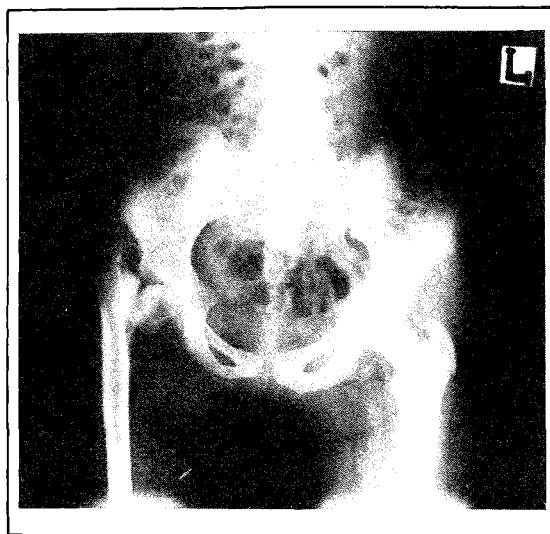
A pre-operative radiograph of Case 3, right hip showing coxa vara, vertical pseudoarthrosis and a beak shaped high riding trochanter.
